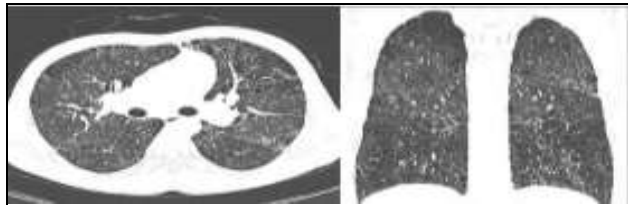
HRCT Thorax of a Known Case of Rheumatoid Arthritis Revealing Reticulonodular Pattern with Hyperinflation and Extensive Areas of Centrilobular and Paraseptal Emphysema with Overinflation and Extensive Fibrosis
